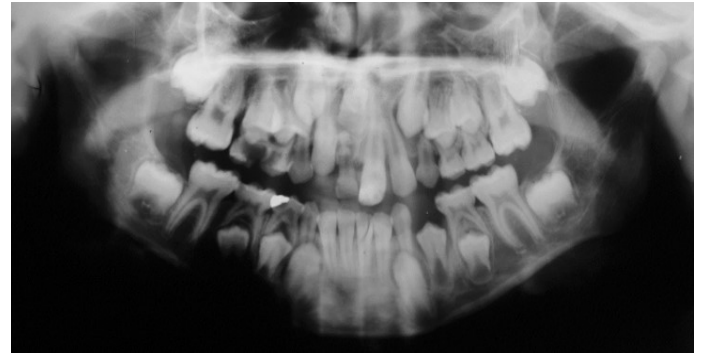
Pretreatment panoramic radiograph revealed compound odontoma under impacted maxillary incisor.
